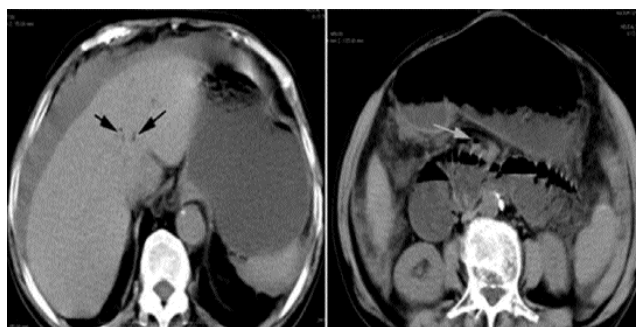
Computed tomography of abdomen showed gas in the main portal vein (black arrows) and mesentery (white arrow).
